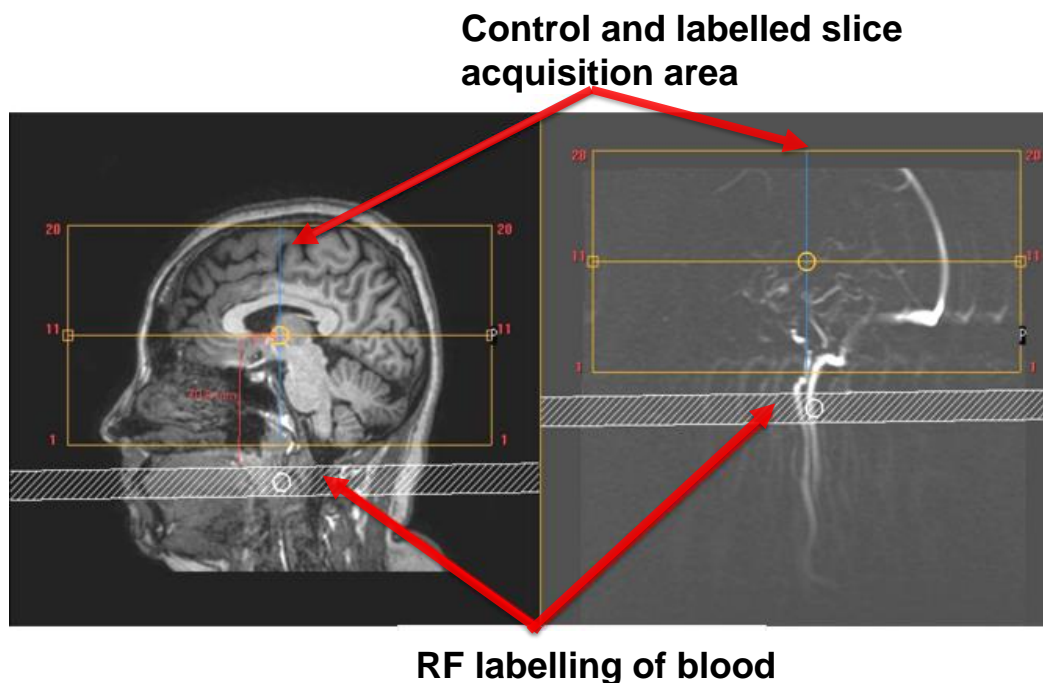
MRI planning of PCASL on T1w sagittal (left) and fast PC-MRI (right) showing slice acquisition and RF labelling planes. (Images are from the SABRE v3 study).
